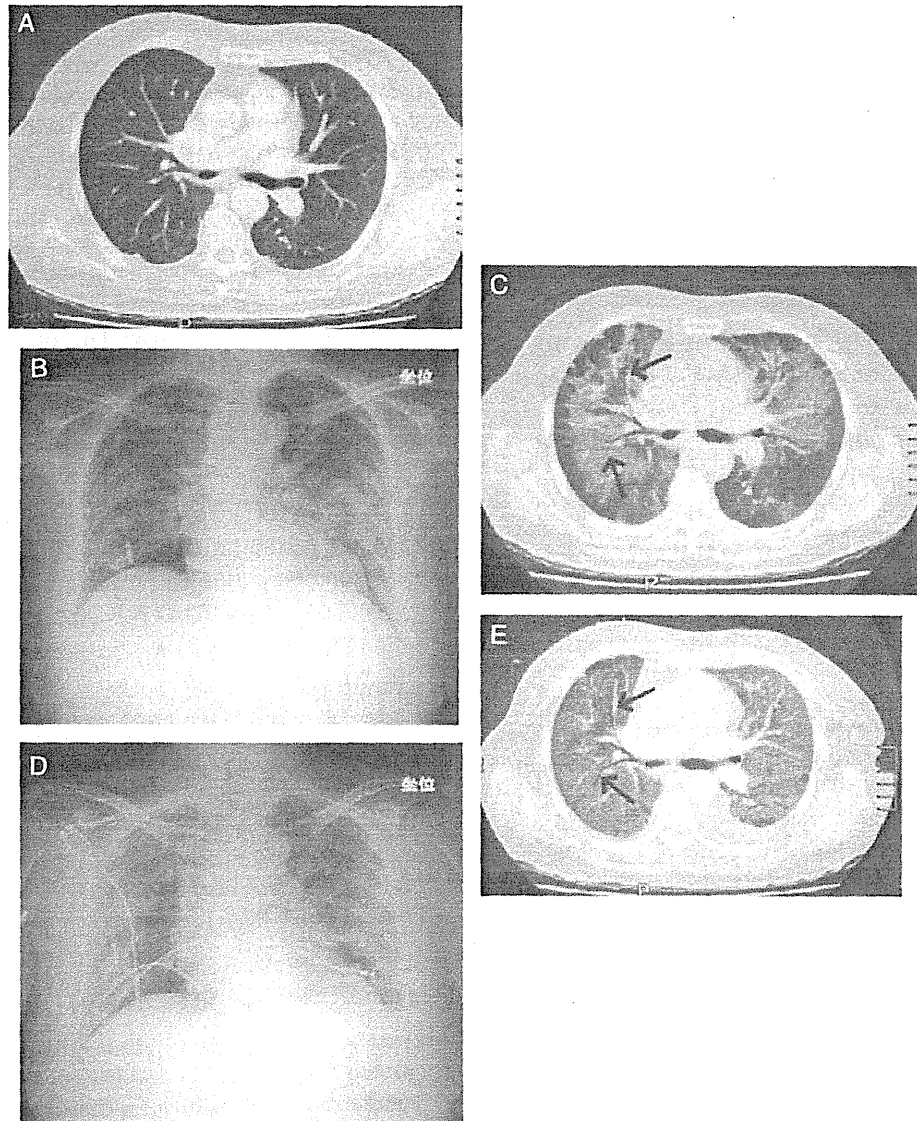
Case report of a female patient with recurrent colorectal cancer in her 60s. (A) Image before the onset of DLI taken at 32 days after starting cetuximab therapy. Metastatic nodes were observed in the inferior lobe of both lungs. An infiltrate and ground-glass opacity were not observed. (B) X-ray image taken 60 days after starting cetuximab therapy, 3 days after the onset of symptoms. Ground-glass opacity was predominantly observed in the bilateral upper lung field. (C) Computed tomography (CT) scan on Day 60. Ground-glass opacity was observed from the hilus to the middle section of both lungs. The lesion in the periphery of the lung field was lightly spared. Hypertransradiancy of bronchi (arrow) was observed, but there was no obvious traction bronchiectasis, and it could not be diagnosed as diffuse alveolar damage from the images. (D) X-ray image taken on Day 67. The abnormal shadows in both lung fields had spread and were exacerbated. (E) CT image taken on Day 68. The shadows in both lungs were exacerbated and extended to the periphery of each lung. Hypertransradiancy of bronchi with bellows-like dilation (arrow) was observed in the shadows, and was considered to be traction bronchiectasis. The organizing stage of diffuse alveolar damage was observed, which was considered to be a sign of lesion progression. Left pleural effusion was also observed.
